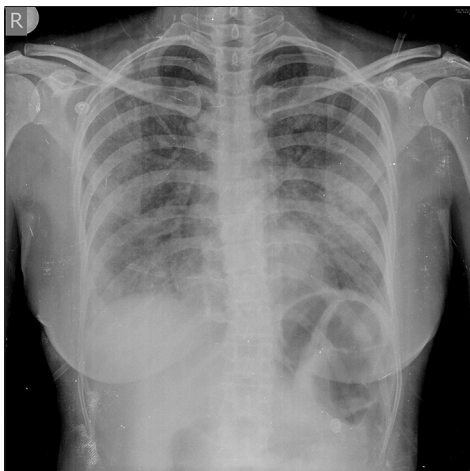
Chest radiograph of the patient one at admission
